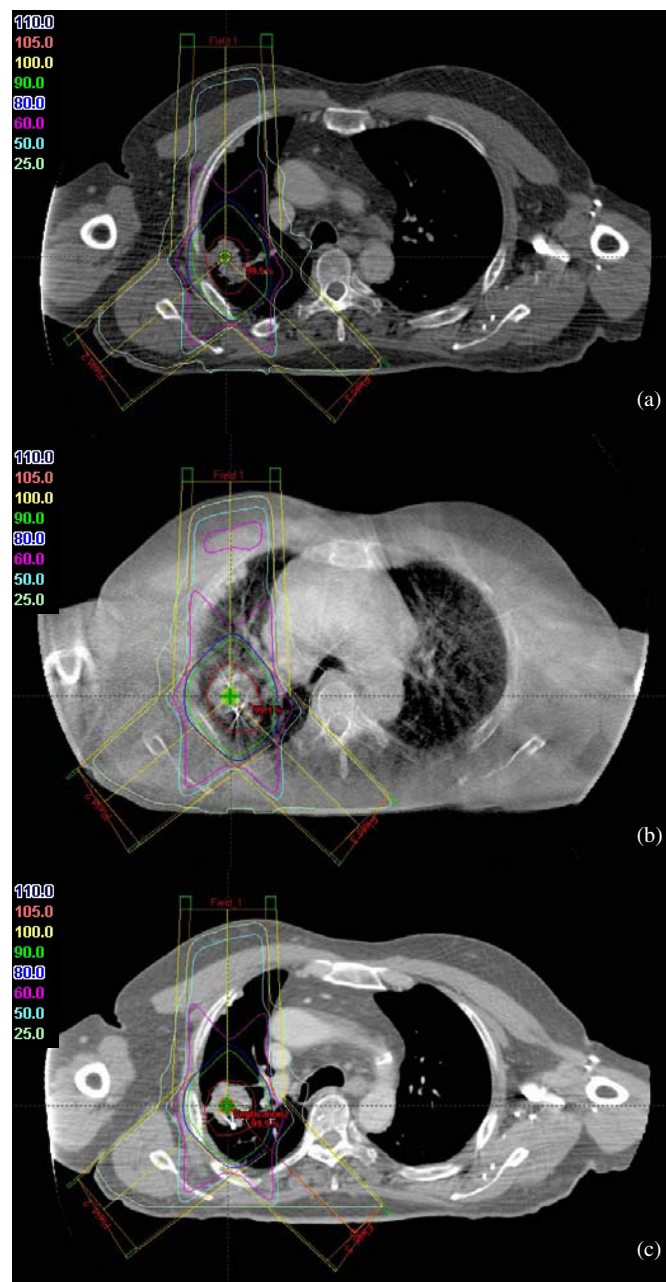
Dose distribution in a transverse slice calculated based on (a) planning CT; (b) CBCT; and (c) modified CBCT for the lung case. A comparison of the DVHs of GTV, PTV, right lung and spinal cord obtained based on planning CT, CBCT and the modified CBCT images is shown in (d).
